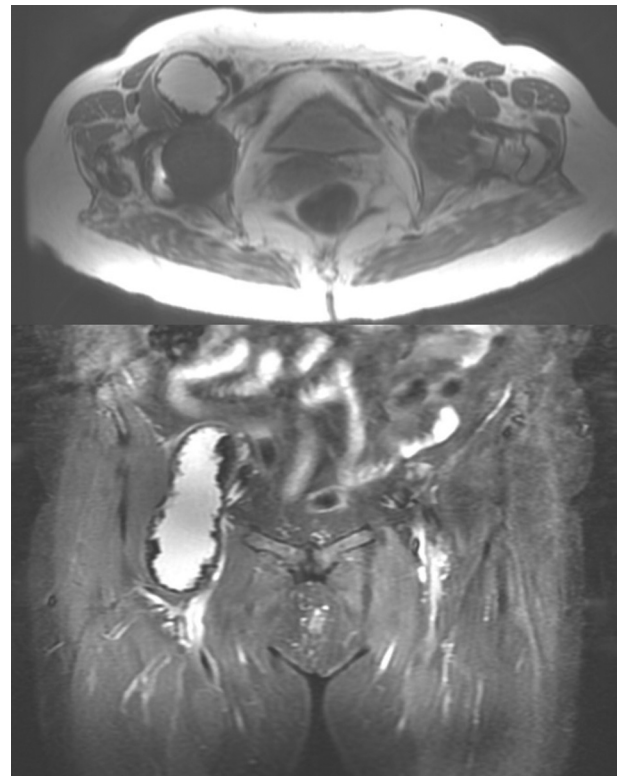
Axial (T1) and coronal (T2) metal suppression magnetic resonance images of patient now 7.5 years out from simultaneous bilateral CoM THA notable for unilateral (right) cystic lesion (T1 and T2 hyperintense, pseudocapsular disruption, tracking anteriorly/proximally).
